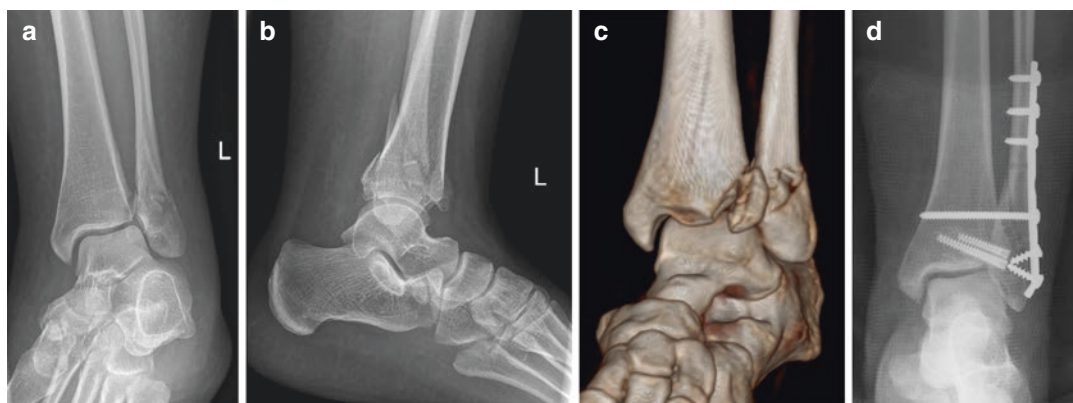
(a) AP X-ray of a Weber B distal fibular fracture in a professional football player. (b) Lateral X-ray reveals the combined bony anterior syndesmotic fracture.
